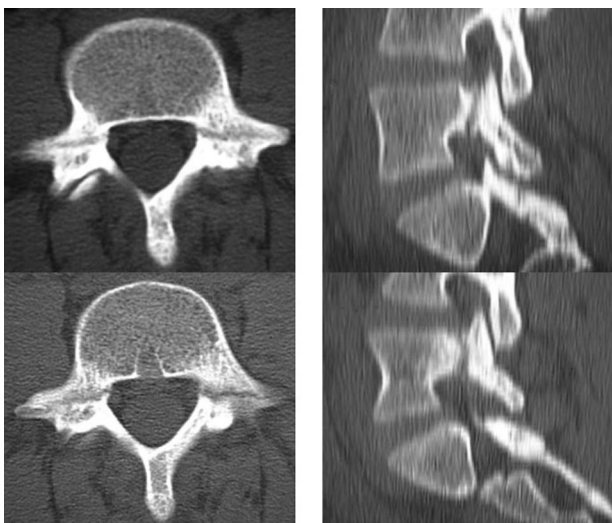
Axial CT sections (left) and sagittal reconstructions (right) confirm bilateral L5 pedicle fractures.
